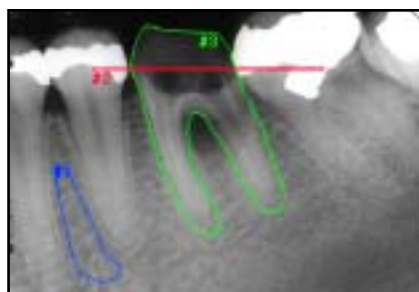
Linear radiographic measurements from reference line (#2) to crestal bone levels: image taken before tooth extraction (I_{BX}). The contour of the tooth (#3) has been drawn in this image. #1 = ROC.
